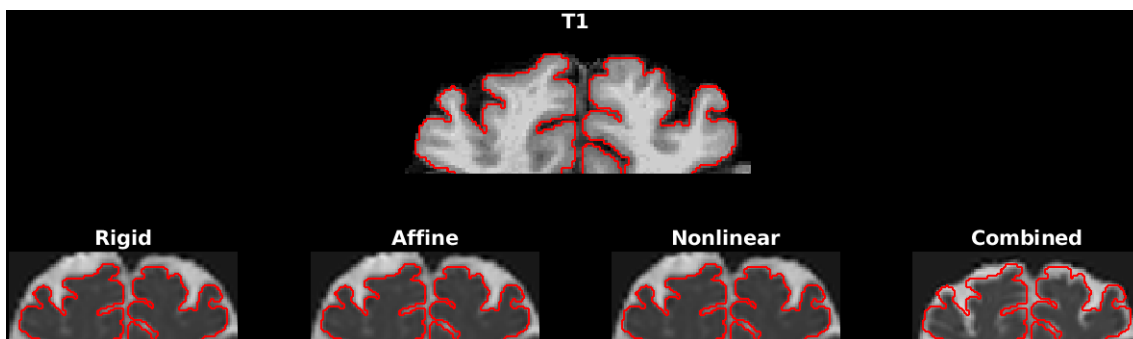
The outlining of the T1-weighted image in the anterior part of the brain, together with the four registration approaches (driven by b_{2500}) used where the outlined mask is applied on the MD-image.
